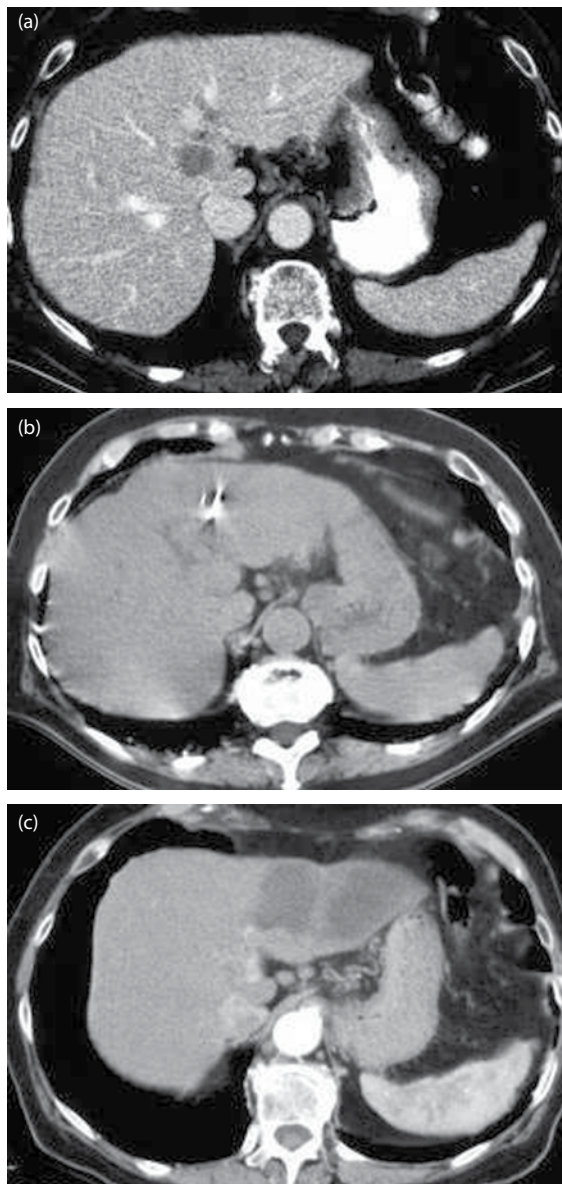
Devascularization injury from MWA close to portal pedicle of liver segments II/III. (a) Preablation CT with caudate lobe lesion. (b) MWA of the lesion located near the left portal pedicle. (c) Postablation image showing necrosis of segments II and III. (With kind permission from Springer Science+Business Media: *The SAGES Manual on the Fundamental Use of Surgical Energy [FUSE]*.)
